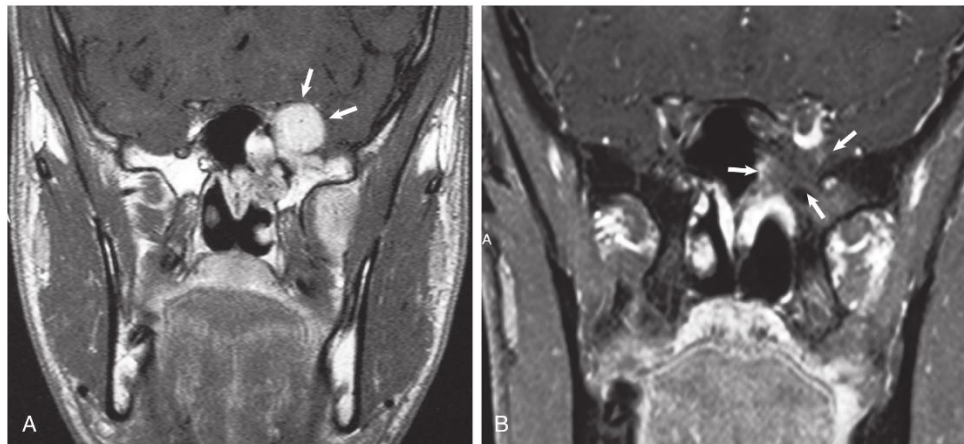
Juvenile angiofibroma on coronal contrast-enhanced magnetic resonance images (MRIs) obtained before and after endoscopic resection. A, Pretreatment image shows encroachment of both the floor and lateral wall of the left sphenoid sinus and infratemporal fossa. Intracranial extension is demonstrated in close proximity to the superior orbital fissure (*arrows*). B, MRI obtained after surgical resection shows solid tissue (*arrows*) along the lateral sphenoid sinus wall; the lack of contrast enhancement suggests residual scar tissue.
